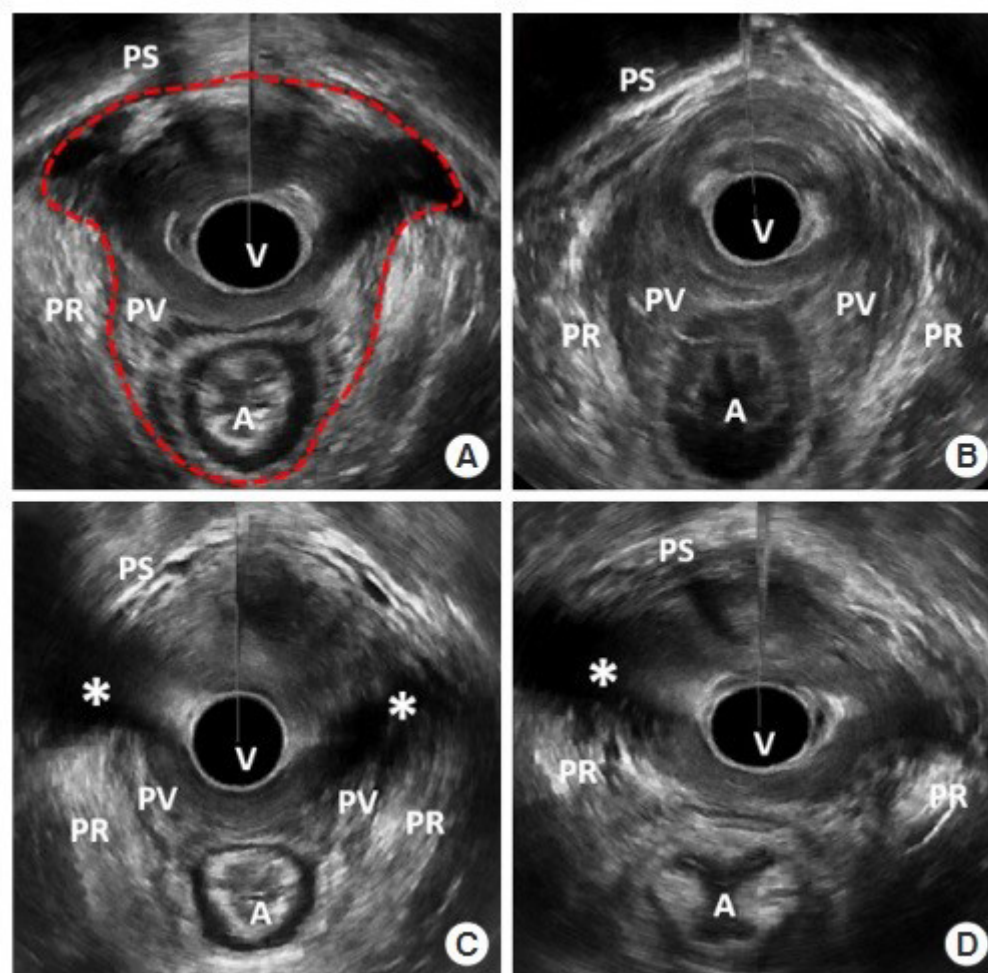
3D-pelvic floor ultrasonography. (A) Minimal levator hiatus (MLH), (B) mild levator ani deficiency (LAD) score, (C) severe LAD score, (D) levator ani muscle avulsion. Red dot-ted line, MLH area; asterisk, avulsion site. A, anus; PR, puborectalis muscle; PS, pubic symphysis; PV, pubovisceralis muscle; V, vaginal [31]. Adapted from Jeong et al. [31] with CC-BY-NC.
